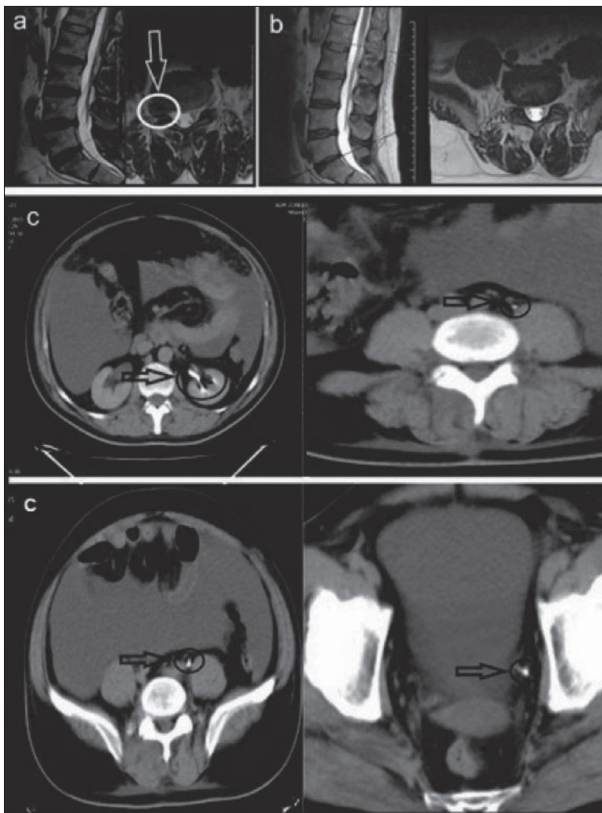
a – Preoperative magnetic resonance imaging showing L5–S1 right far-lateral disc herniation (white arrow and white circle); b – postoperative one-year control magnetic resonance imaging showing no disc; c – contrast-enhanced abdominal computed tomography performed on postoperative day one showing diffuse fluid in the abdomen and contrast enhancement in the left ureter at the edge of the psoas muscle (black arrow and black circle) but not on the side of the injury
